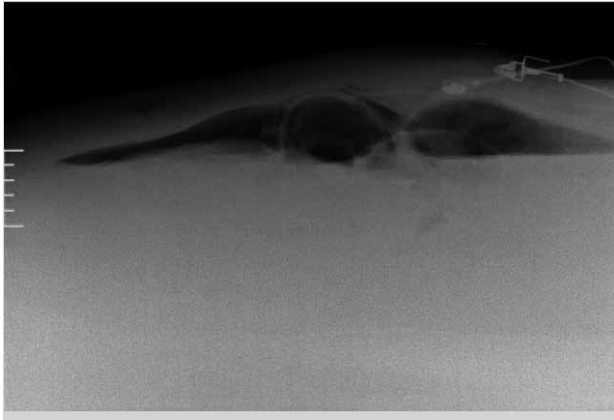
Free intraabdominal air on lateral abdominal X-ray
